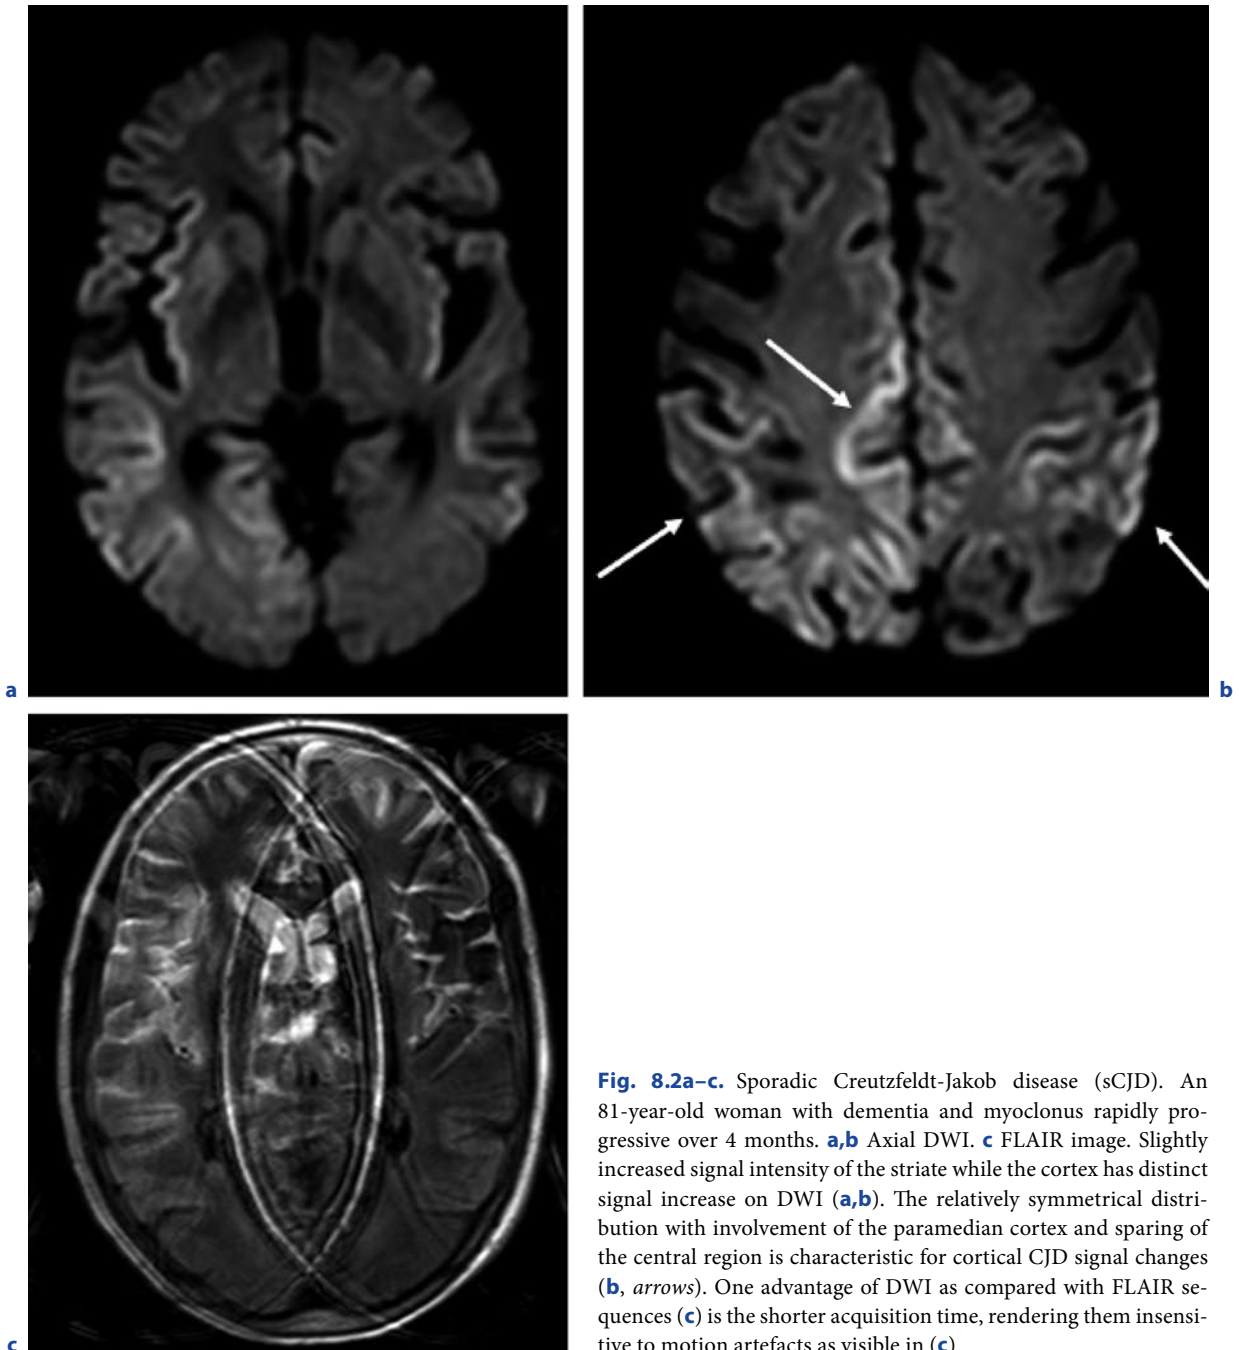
Sporadic Creutzfeldt-Jakob disease (sCJD). An 81-year-old woman with dementia and myoclonus rapidly progressive over 4 months. a,b Axial DWI. c FLAIR image. Slightly increased signal intensity of the striate while the cortex has distinct signal increase on DWI (a,b). The relatively symmetrical distribution with involvement of the paramedian cortex and sparing of the central region is characteristic for cortical CJD signal changes (b, arrows). One advantage of DWI as compared with FLAIR sequences (c) is the shorter acquisition time, rendering them insensitive to motion artefacts as visible in (c)
